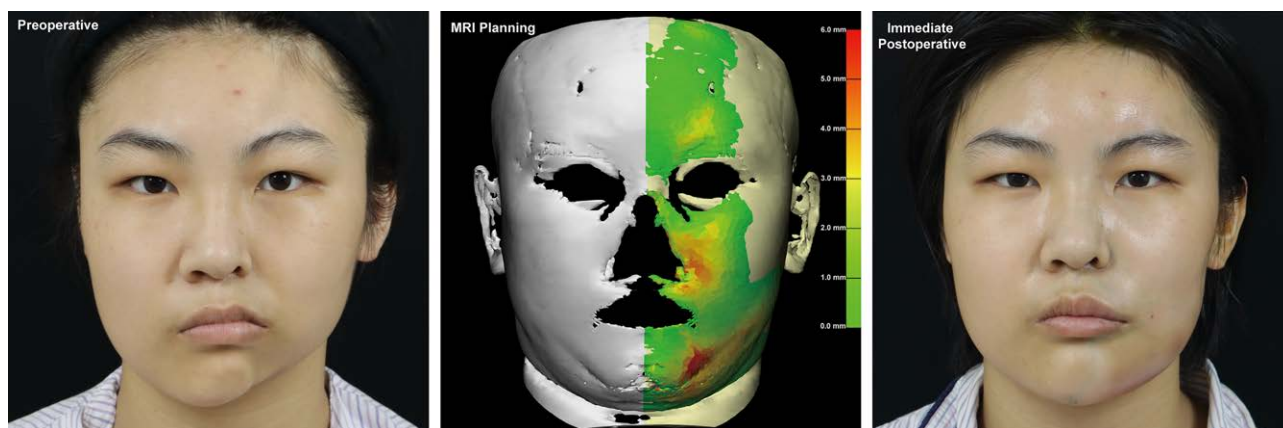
MRI-assisted preoperative planning was performed by comparing the thickness of fat tissue (*center*) on the affected and healthy sides (patient 10). There was moderate overcorrection immediately postoperatively (*right*) compared with preoperatively (*left*).
